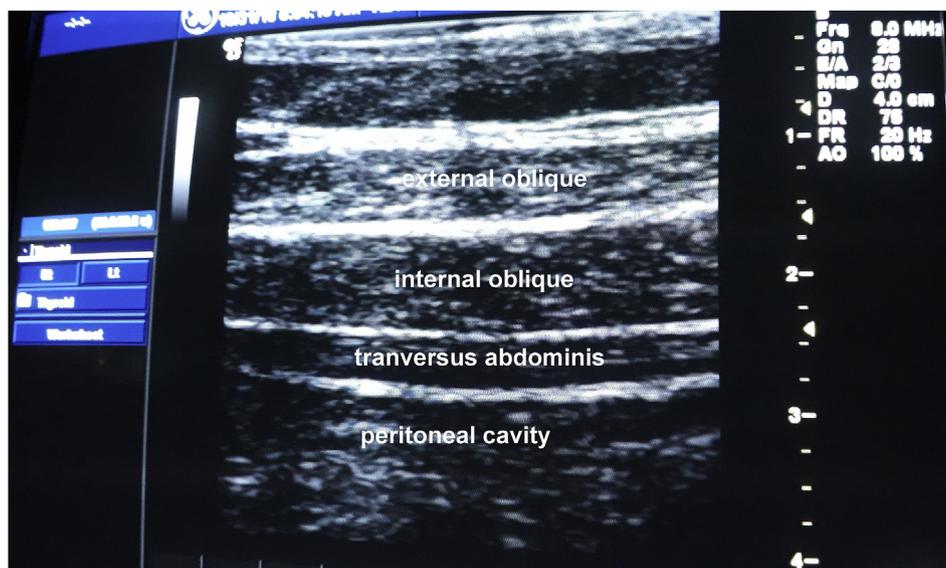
Sonographic view of the three abdominal muscle layers before local anesthetic injection.
